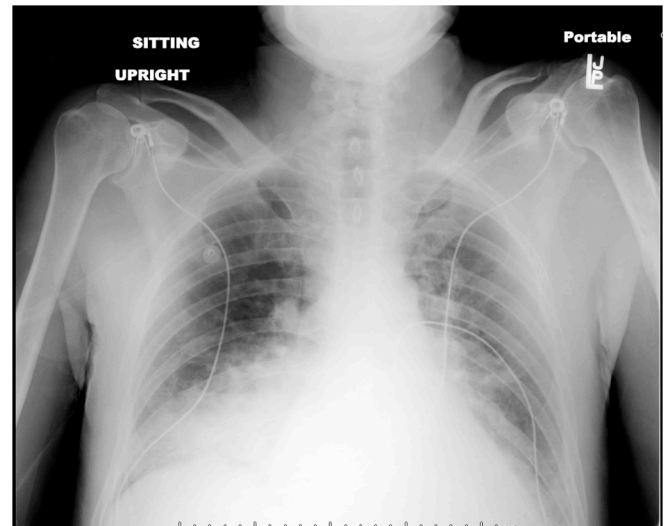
Chest X-Ray following ring removal.
